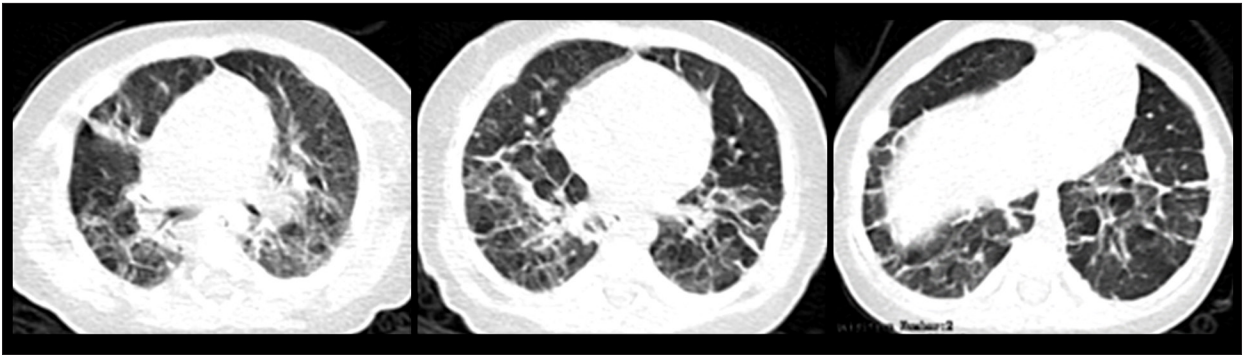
Chest CT before mononuclear cells transplantation.
